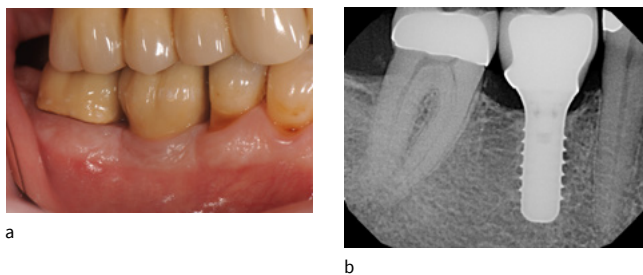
Mandibular molar replaced with an implant-supported crown at 10 years. a: Facial view showing good esthetics and tissue stability. b: Radiograph showing excellent crestal bone maintenance
